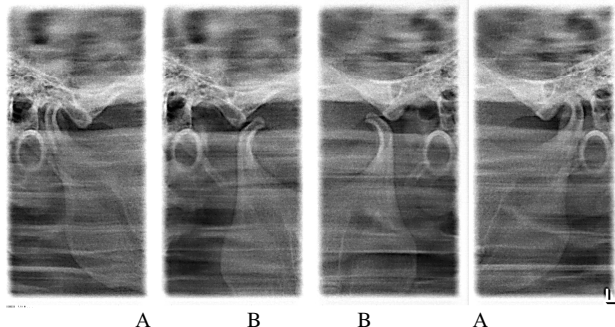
Targeted X-rays of both TMJs of patient with compression-dislocation dysfunction of TMJ. When the mouth is closed (A), the articular cavity of the right joint is sharply narrowed from behind (the condition of compression), and the left joint is enlarged. When the mouth is open (B), the left articular head is significantly displaced anteriorly to the apex of the articular tubercle, the right one is located on the anterior slope of the tubercle.
